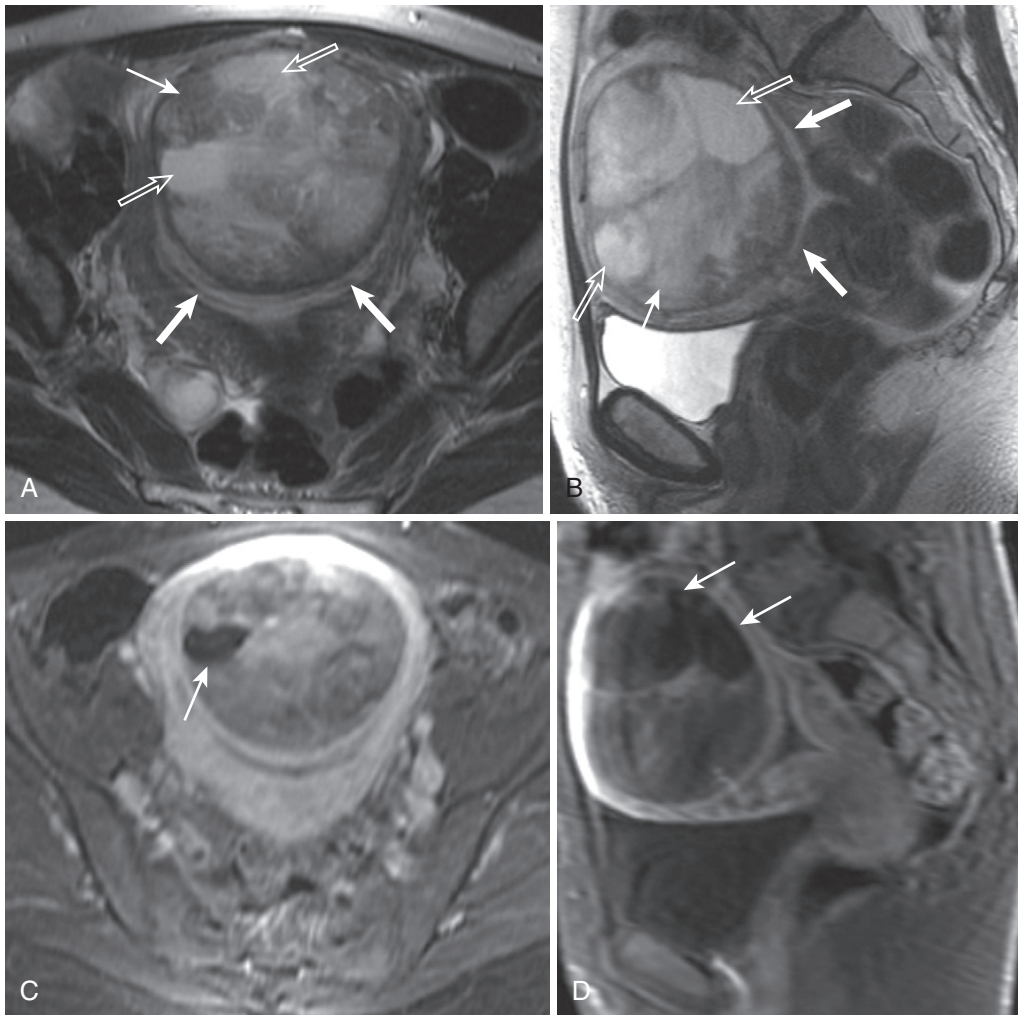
Fibroid with cystic degeneration. Axial (A) and sagittal (B) T2-weighted images of a uterus with a large heterogeneously hyperintense fibroid (*thin arrow* in A and B) with submucosal extension (*thick arrows* in A and B) reveal multiple fluid intensity foci (*open arrows*), which do not enhance (*arrows* in C and D), as seen on the axial (C) and sagittal (D) fat-suppressed T1-weighted images after gadolinium administration.
